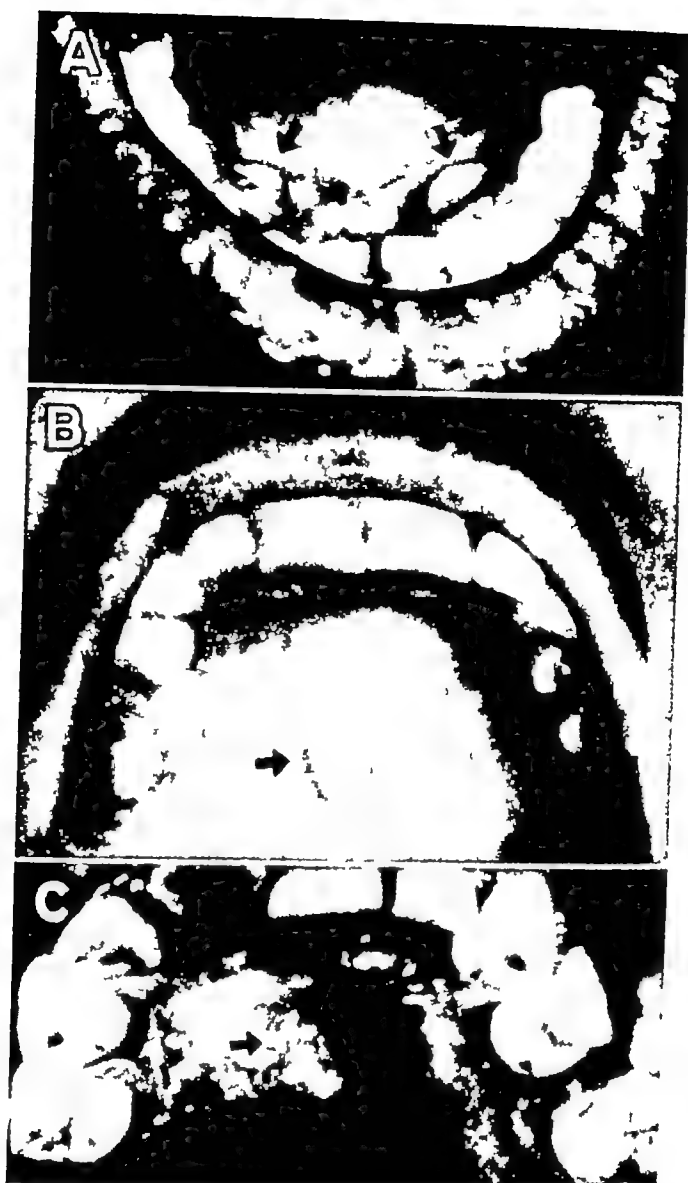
A, bilateral mandibular tori on lingual surface in cuspid region B, midline torus of hard palate, to be differentiated from palatal abscesses and cysts, mixed tumors and carcinoma C, palatal abscess from periapical infection of an upper incisor
